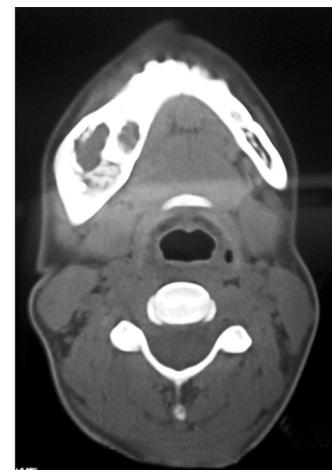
CT axial view showing dense cystic type of fibrous dysplasia affecting right side of the mandible
